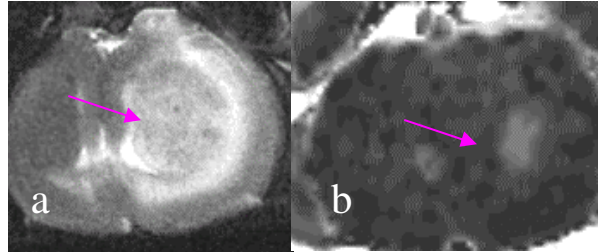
a: A T2-weighted image and b: the corresponding permeability map.
